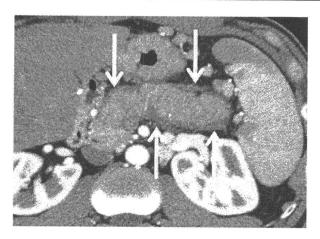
Abdominal CT in AIP (parenchymal phase). The pancreatic parenchyma shows irregularly reduced enhancement. The marginal zone of the pancreas shows a capsule-like rim with more reduced enhancement
